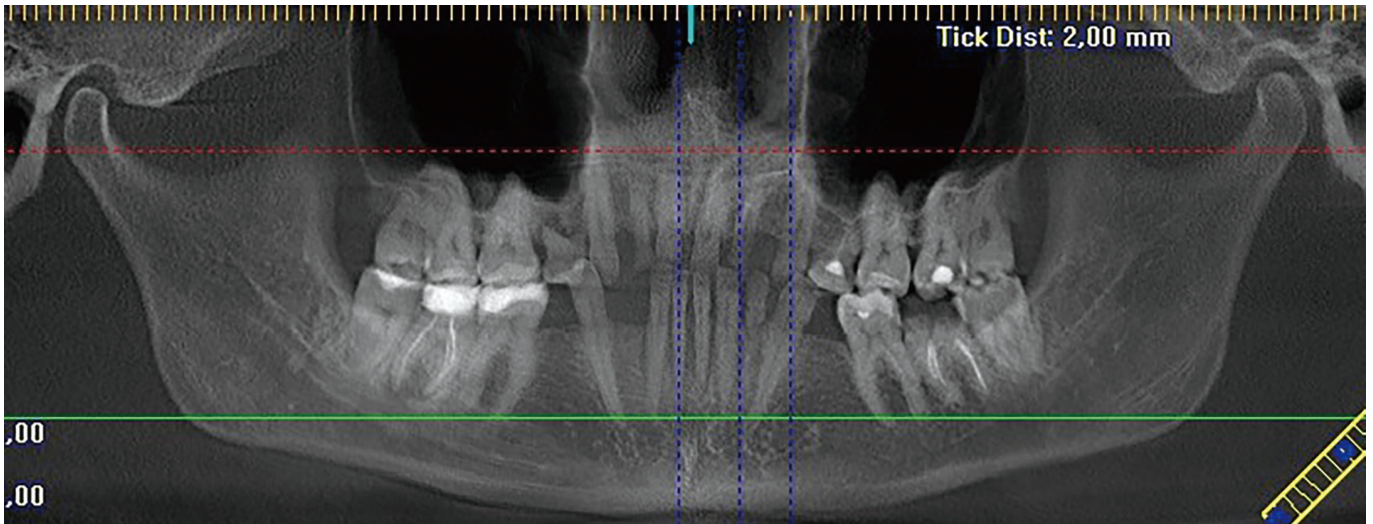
CBCT, panoramic section
